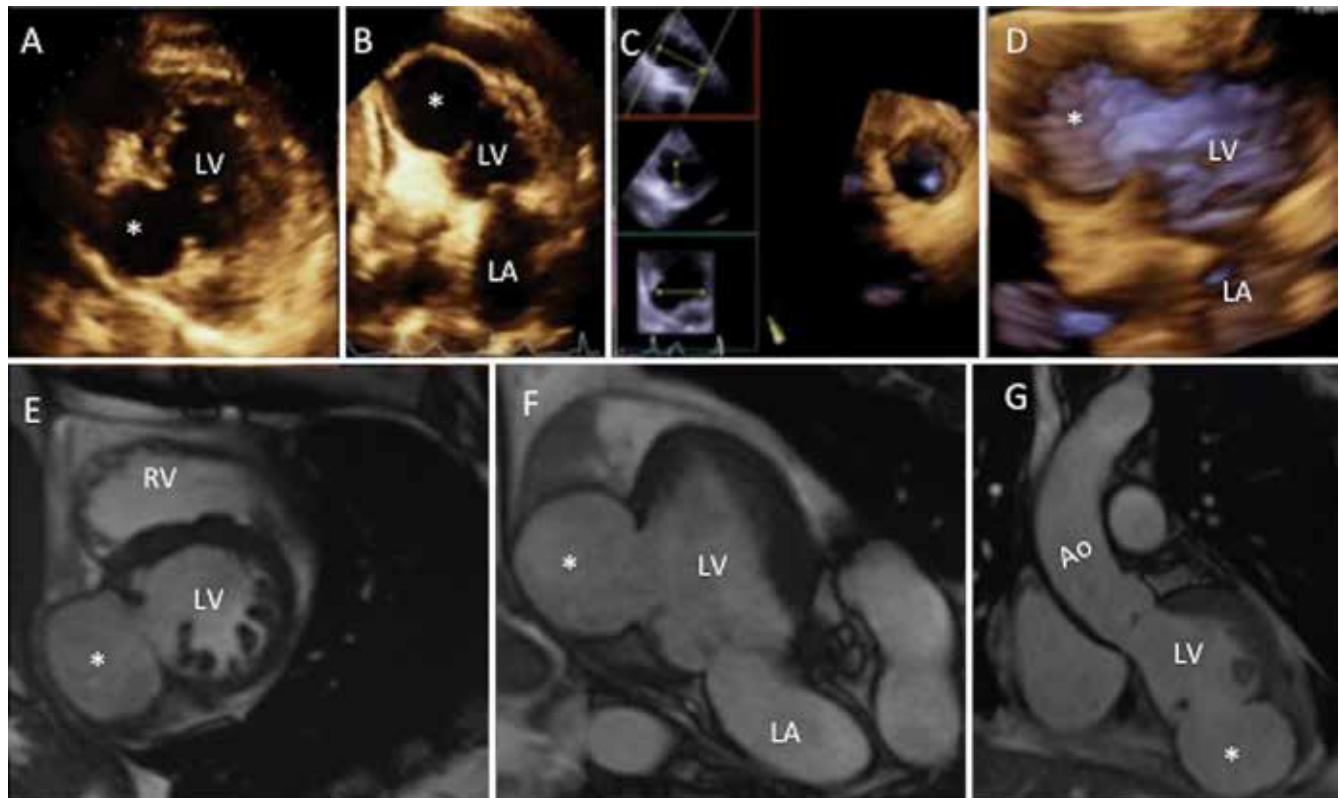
Transthoracic 2D and 3D echocardiogram showing inferior-middle and apical wall akinesia and saccular pseudoaneurysm of 5.6×4.7 cm in the basal and middle segments of inferior and inferolateral walls, with entrance orifice of 2.6×2.4 cm and pericardial effusion A, B, C, D. MRI corroborated these findings E, F, G. *Ao* aorta, *LA* left atrium, *LV* left ventricle, *RV* right ventricle
